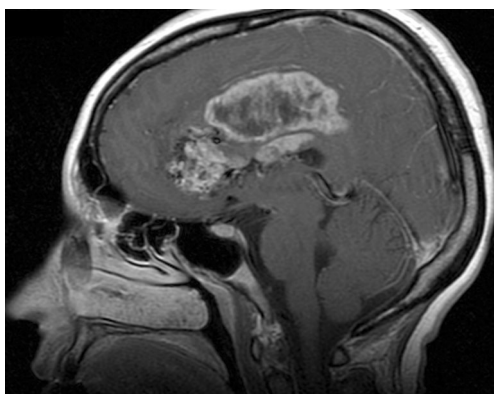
T1-weighted post-gadolinium sagittal magnetic resonance imaging scan demonstrating a mass with peripheral enhancement and central necrosis involving the right mesial frontal lobe with extension into the corpus callosum
